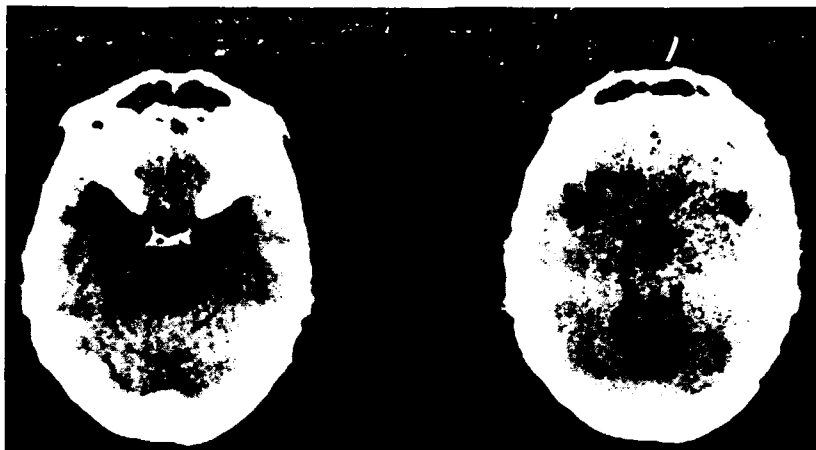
CT of a case with Friedreich's ataxia.
